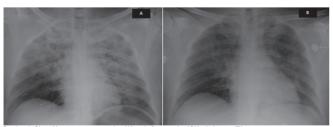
Chest X-ray upon presentation (A) and after one day ICU admittance (B).
